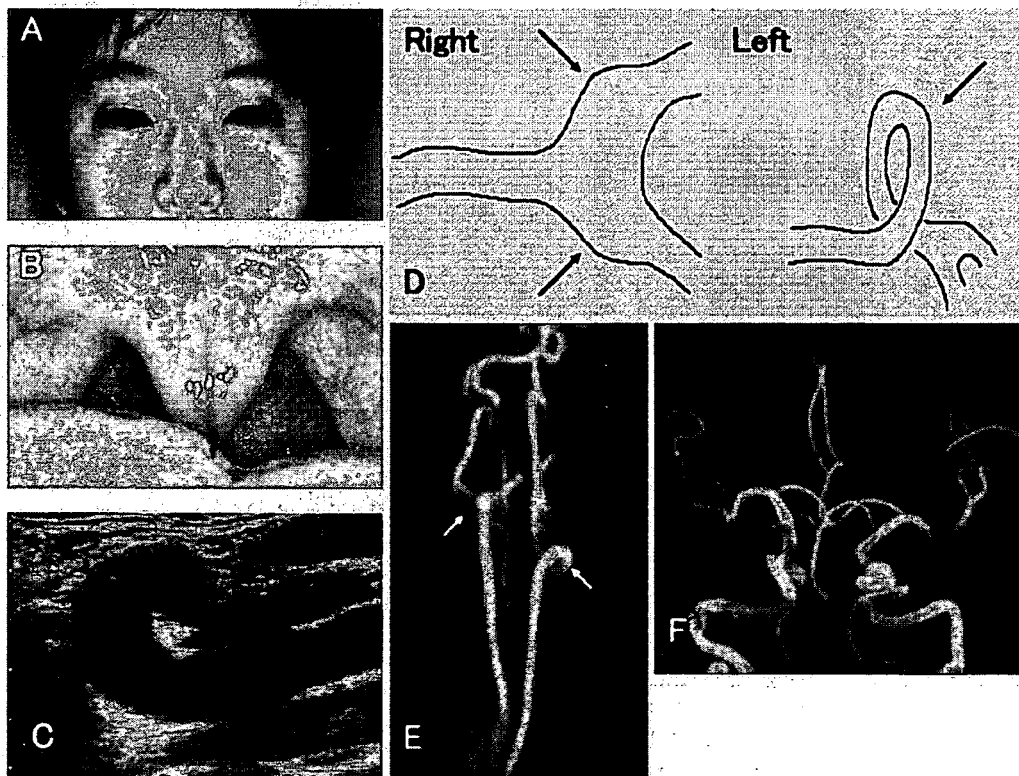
The clinical findings of the patient. A: Hypertelorism. B: Bifid uvula (arrow). C: Carotid ultrasonography showing a left common carotid artery loop. D: A carotid aneurysm and arterial tortuosity visualized by carotid ultrasonography (arrows). The left common carotid artery formed a loop. E: Carotid MRA showing a right carotid aneurysm and a left common carotid artery loop (arrows). F: Cerebral MRA showing cerebral arterial tortuosity.
